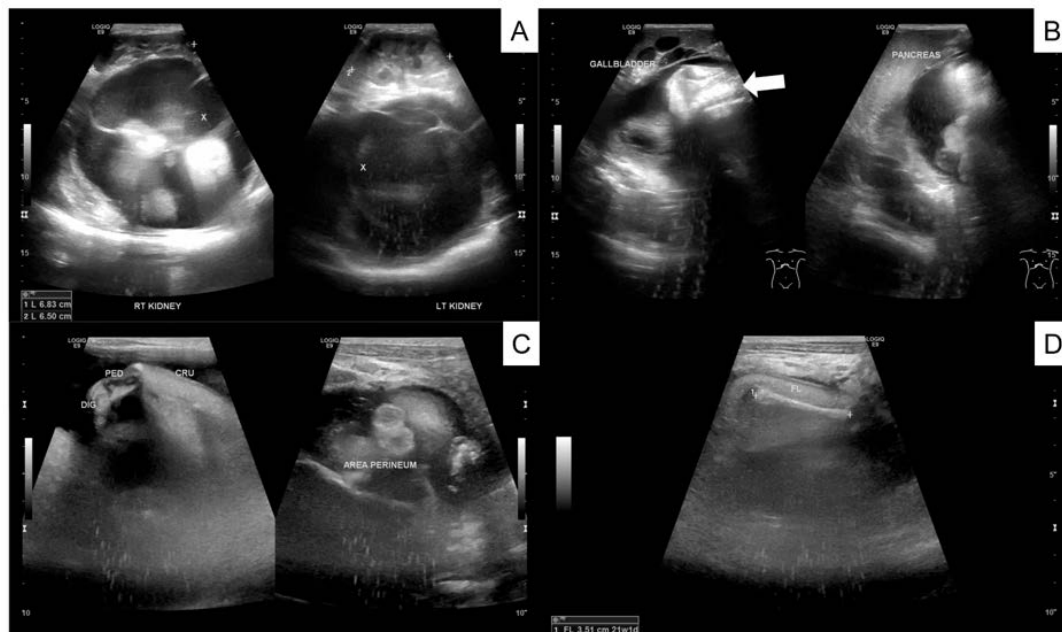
Abdominal ultrasonography of a 4-month-old male with fetus in fetu showed (A) a large mass in the abdominal cavity, mixed echo, with predominant anechoic structure and solid components. (B) Spine structure (arrow) along with (C) lower limb, foot, and toes' structure was seen inside the mass. (D) The femur bone was seen with an estimated length resembling a 21-week-old fetus.
